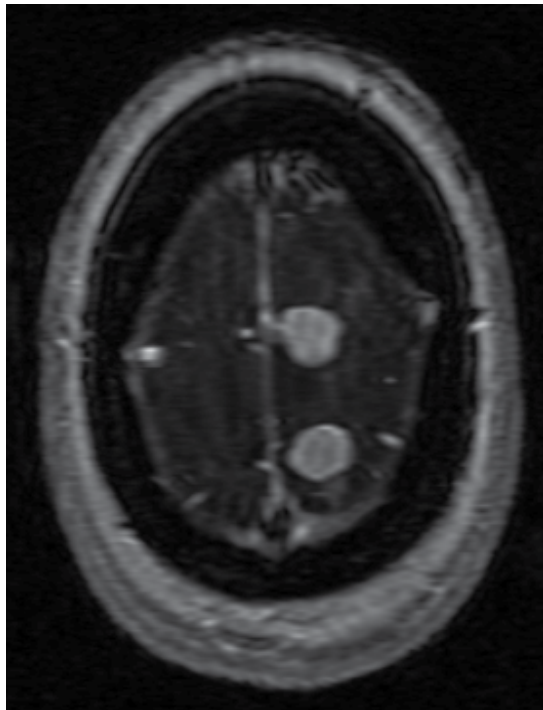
Axial T1 MRI with gadolinium of the left sided convexity meningiomas in a 62-year old woman. Anterior lesion has visible dural tail.
